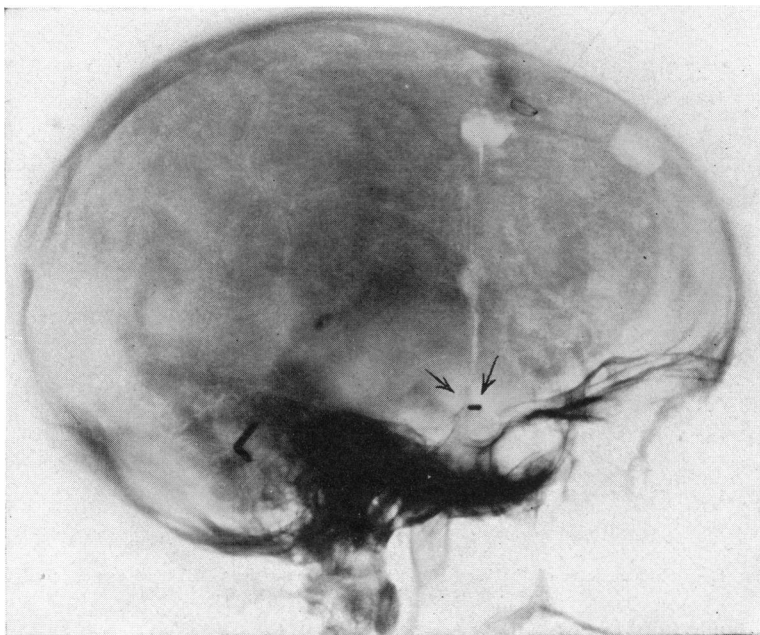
Roentgenogram showing the silver clip at the sella turcica. It also shows the size and position of the bone flap.
